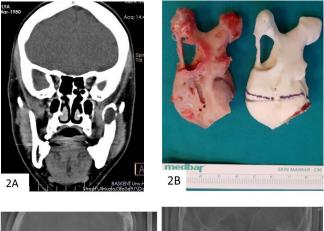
(A) CT imaging of the patient having recurrent keratocysts.(B) Resection of condyle and ramus was performed in accordance with the 3D surgical planning. (C) Lateral cephalometric radiograph of the patient after surgery. (D) Anteroposterior radiograph of the patient after surgery.
